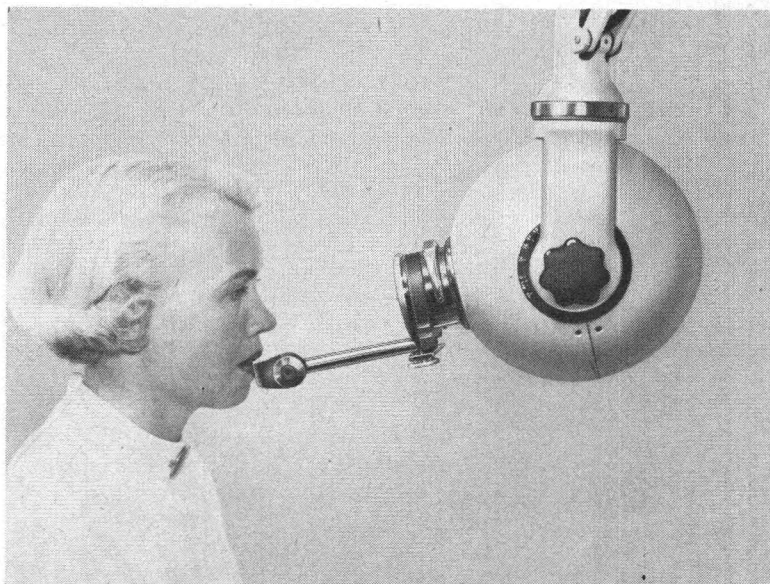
Relation between the positions of patient and apparatus when radiographing lower incisal region.
